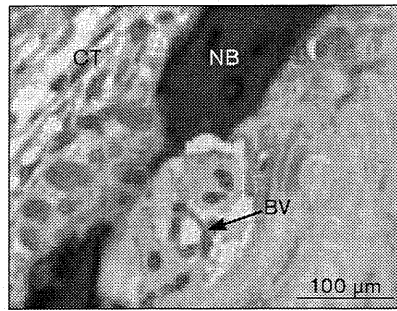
Higher magnification of the circled area in the upper part of Fig 3a (original magnification $\times 100$). CT = connective tissue; NB = newly formed bone; BV = blood vessel.
